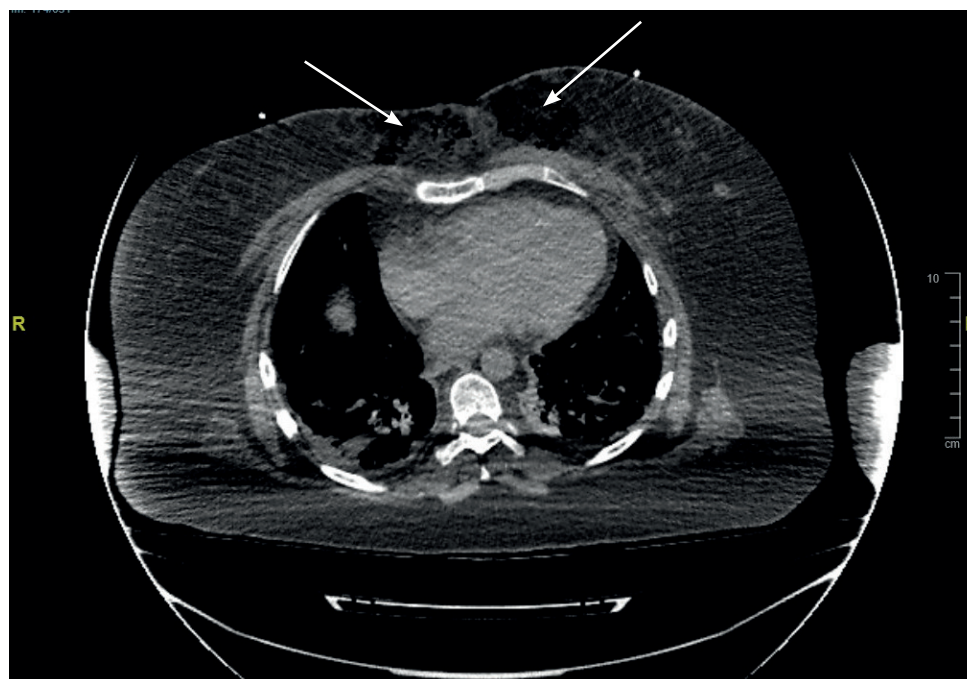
Computed tomography scan of the patient in Figure 1. Note the presence of gas in the soft tissues as indicated by the arrows.
